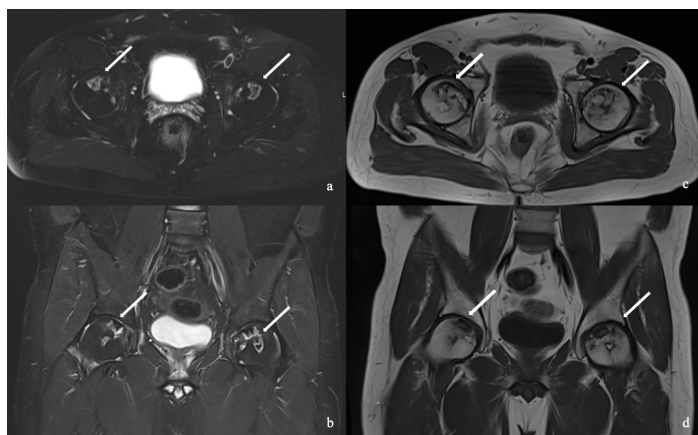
T2-weighted axial (a), coronal (b), T1-weighted axial (c), and coronal (d), images of the case 2 with steroid-induced osteonecrosis showing areas of necrosis in the bilateral femoral head
